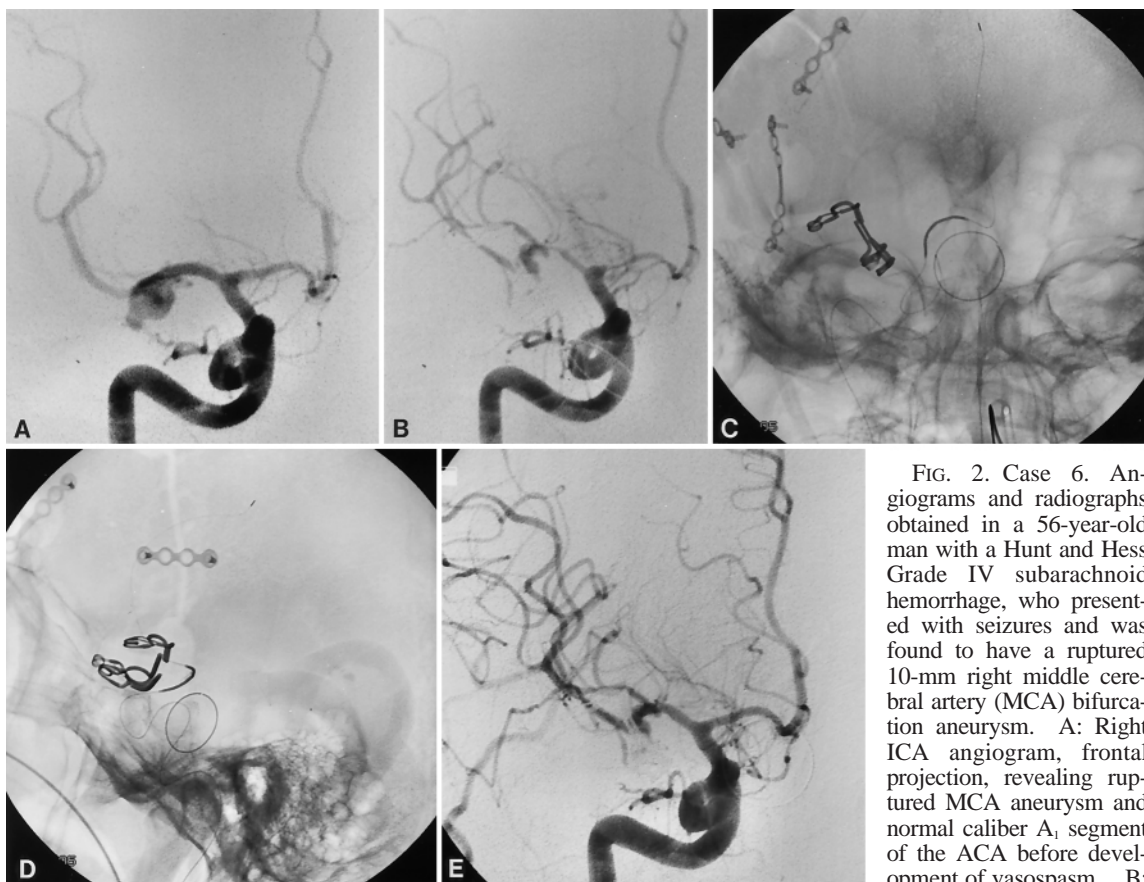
Case 6. Angiograms and radiographs obtained in a 56-year-old man with a Hunt and Hess Grade IV subarachnoid hemorrhage, who presented with seizures and was found to have a ruptured 10-mm right middle cerebral artery (MCA) bifurcation aneurysm. A: Right ICA angiogram, frontal projection, revealing ruptured MCA aneurysm and normal caliber A₁ segment of the ACA before development of vasospasm. B:
